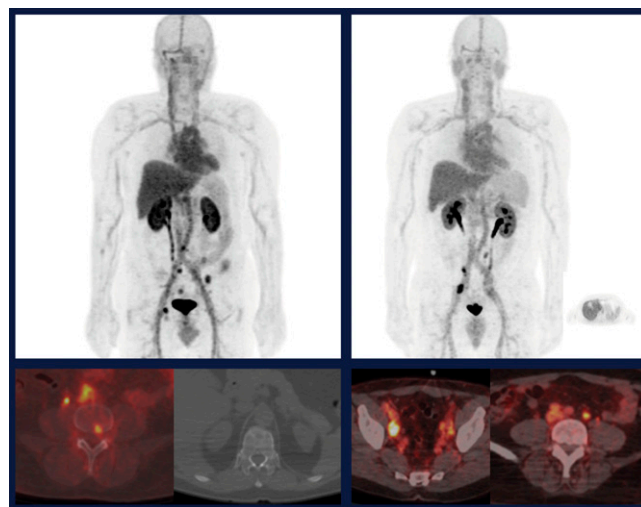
^{18}F -DCFBC low-molecular-weight prostate-specific membrane antigen PET imaging in detection of metastatic and primary prostate cancer. Left: in a patient with bone metastases. Right: In a patient with lymph node metastases. Results with this agent correlated with PET/CT imaging results (bottom rows).
